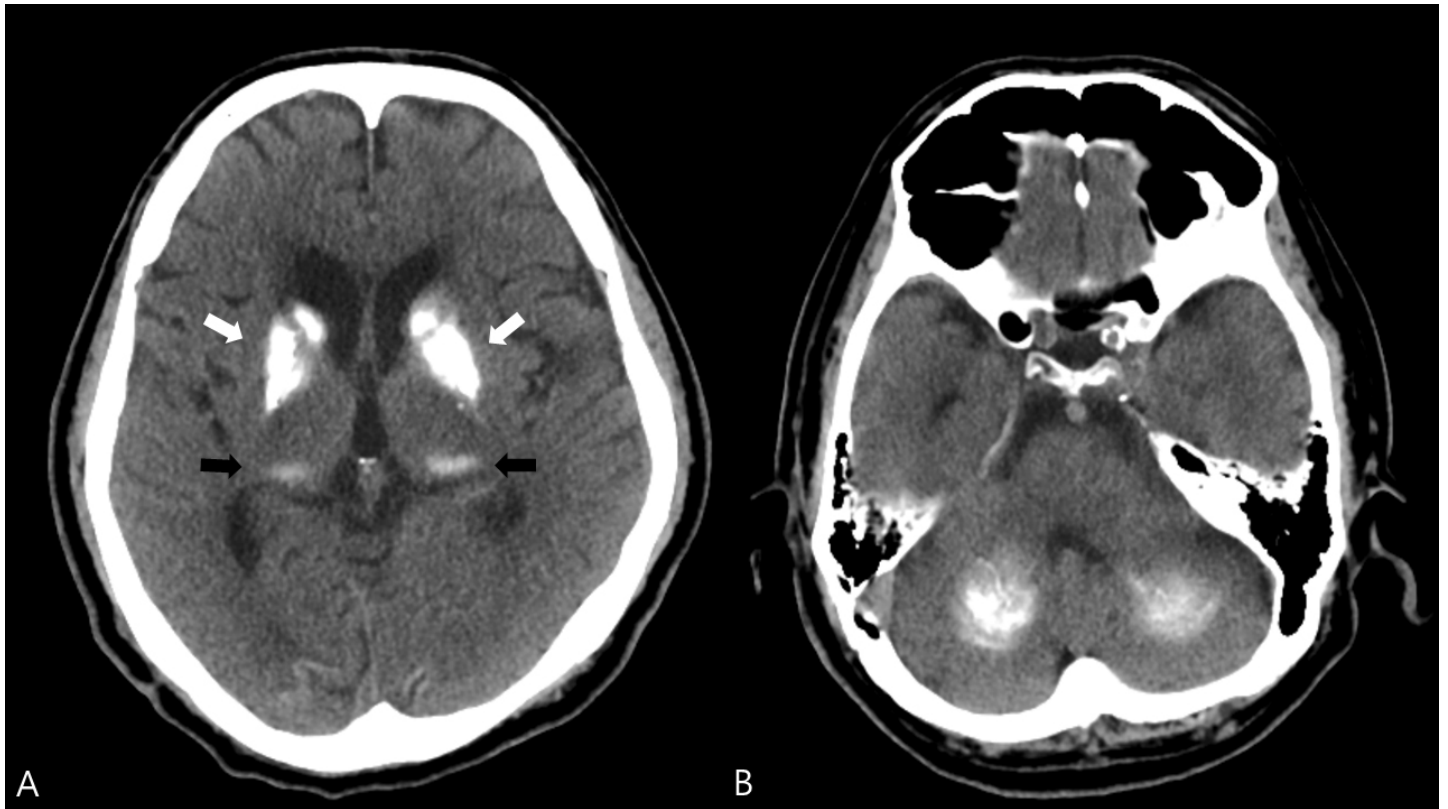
Brain CT scans showing symmetric calcifications. (A) Basal ganglia (white arrow) and thalamus (black arrow), and (B) dentate nucleus of the cerebellum.
